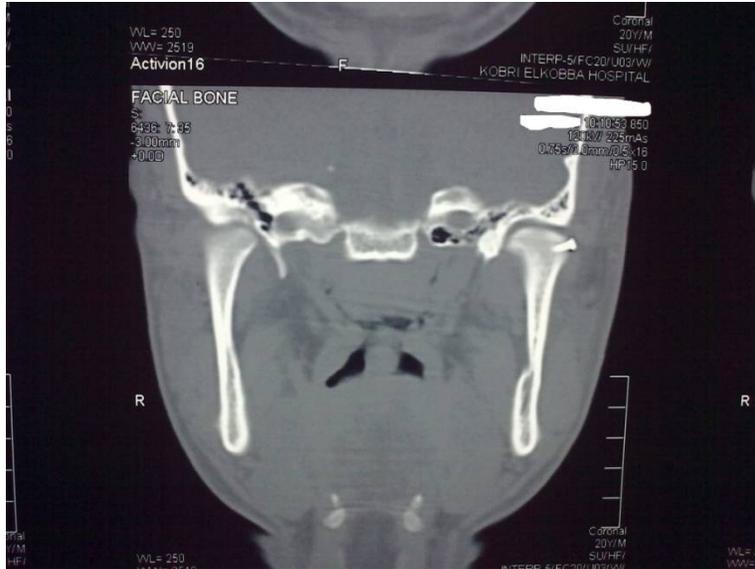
Postoperative CT.
